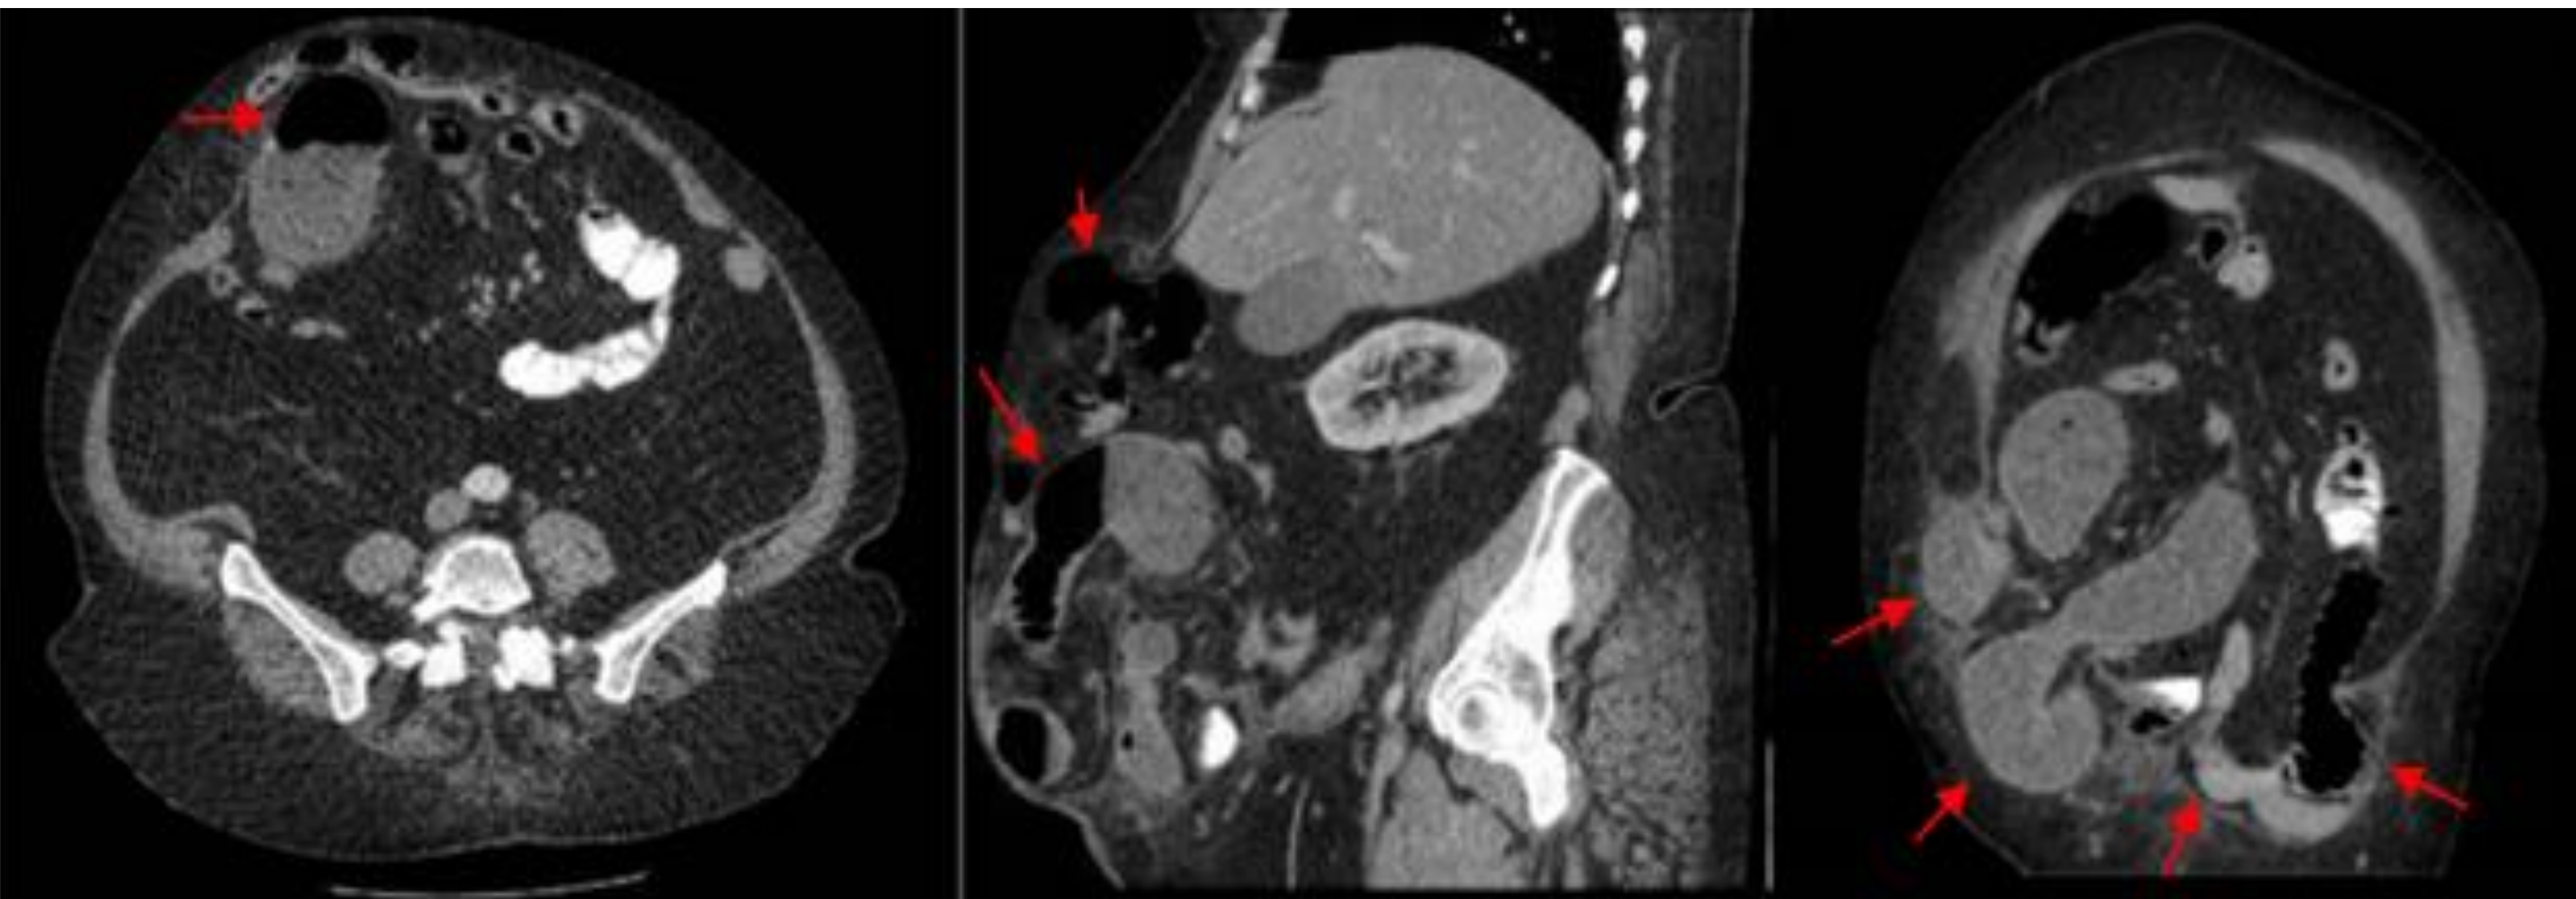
Axial, sagittal and coronal view of CT Abdomen/Pelvis with oral and IV contrast on initial presentation identifying complex small bowel obstruction with multiple ventral abdominal wall hernias.
